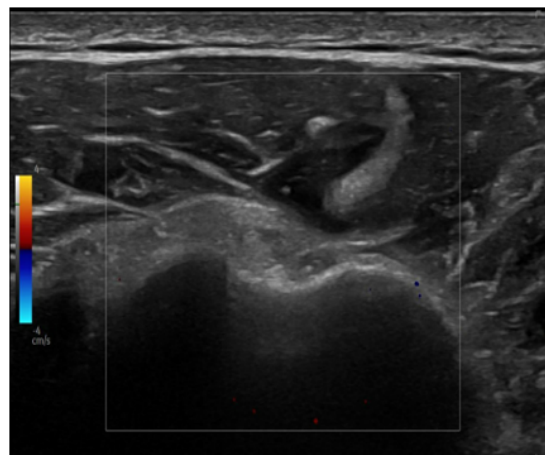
Ultrasound left shoulder showed there was limited external rotation, and mild distention of the biceps tendon sheath most likely indicating adhesive capsulitis/frozen shoulder.
